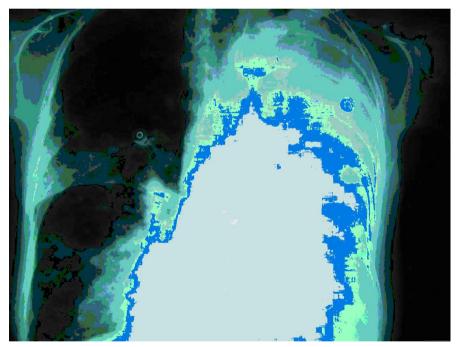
Bronchoalveolar carcinoma causing radiographic appearances of consolidation mimicking pneumonia.
